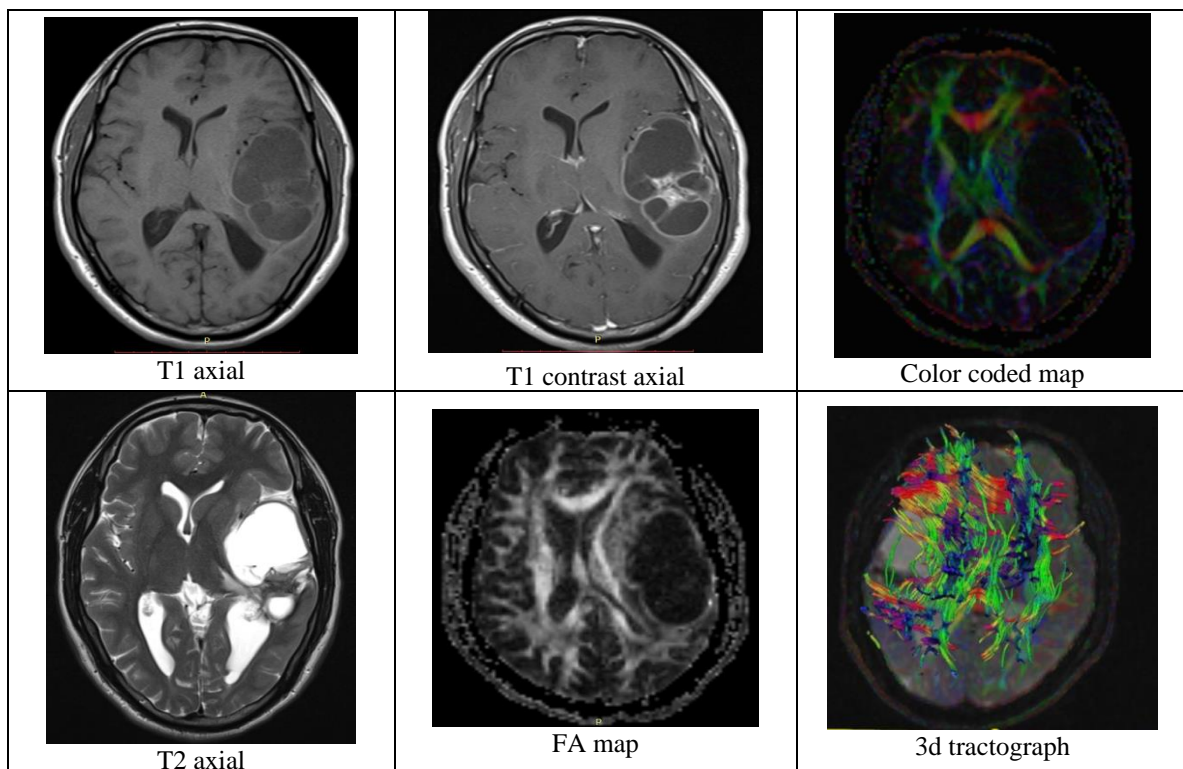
A Thirty year old male patient with cystic meningioma: MRI shows a large lobulated extra axial T1 hypointense T2 hyperintense lesion in left temporo parietal region with multiple T2 hypointense internal septations. Post contrast study shows rim enhancement. The lesion is showing displacement of internal, external capsule, inferior occipitofrontal fasciculus, corona radiata, corticospinal tracts. Significant reduction in FA was noted within the lesion and in perilesional edema.
